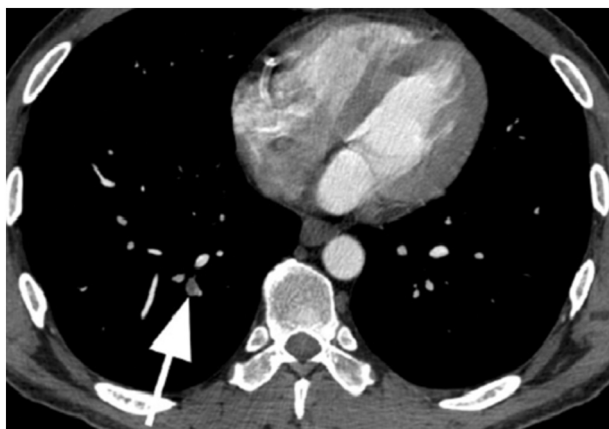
PE-protocol chest computed tomography showing a right lower lobe segmental pulmonary embolism (arrow).
